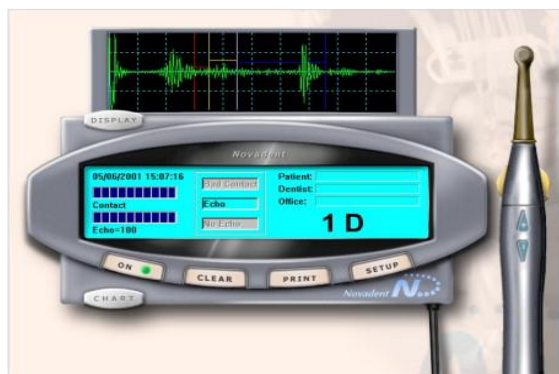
Ultrasound Caries Detector
